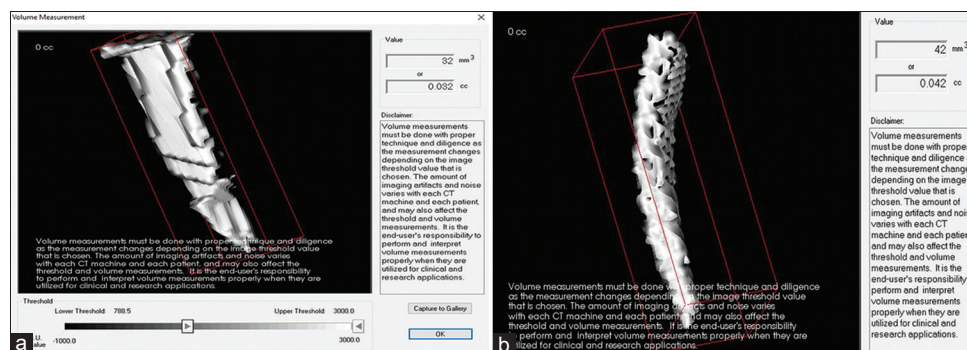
(a and b) Pre- and post-operative scan calculating volume of the canal using cone-beam computed tomography
